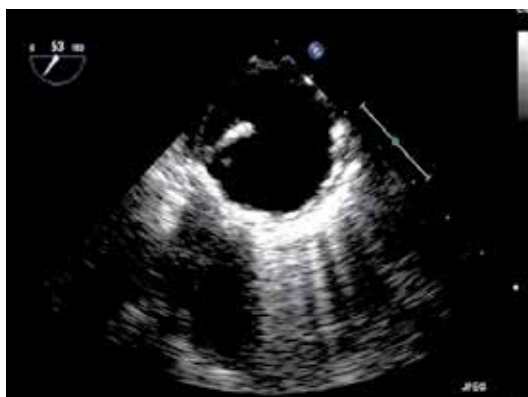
Transoesophageal echocardiography and aortic debris
